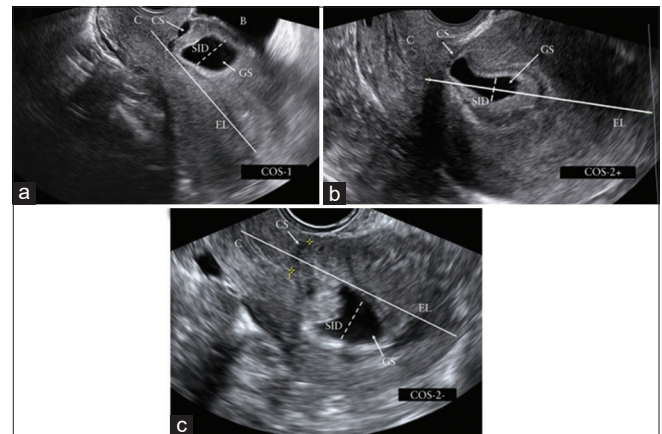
Images of various crossover sign types on ultrasound in cesarean scar pregnancy. (a) Crossover sign-1; (b) crossover sign-2+; (c) crossover sign-2-. B: bladder, C: uterine cervix, CS: cesarean scar, EL: endometrial line, GS: gestational sac, SID: superior-inferior diameter of gestational sac^[5]
